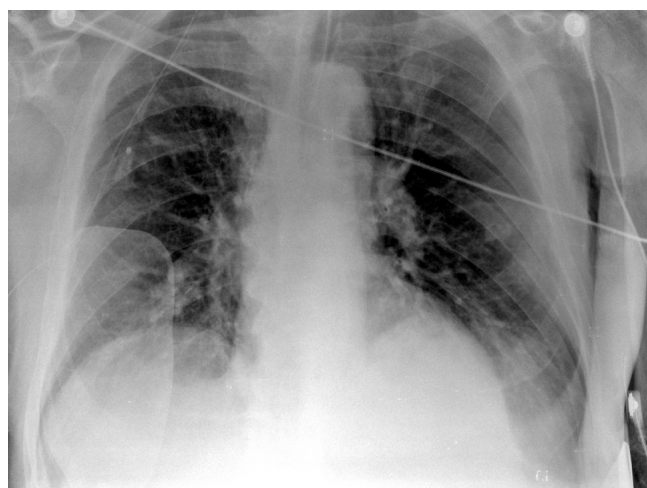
Supine radiograph: Deep Sulcus Sign indicating a left pneumothorax.
